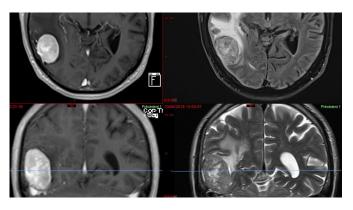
MRI appearance of an haemangiopericytoma preoperatively mistaken for a meningioma
